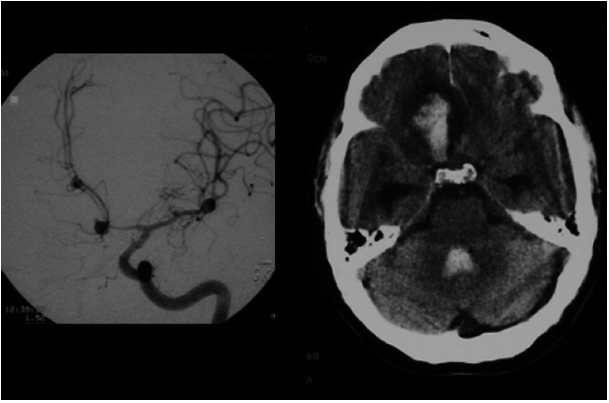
A left anterior communicating artery aneurysm which caused intracerebral haemorrhage which can be seen both in the right frontal region. Blood is also visible on CT in the fourth ventricle. The aneurysm is visible on the angiogram. © Hugh Markus.
